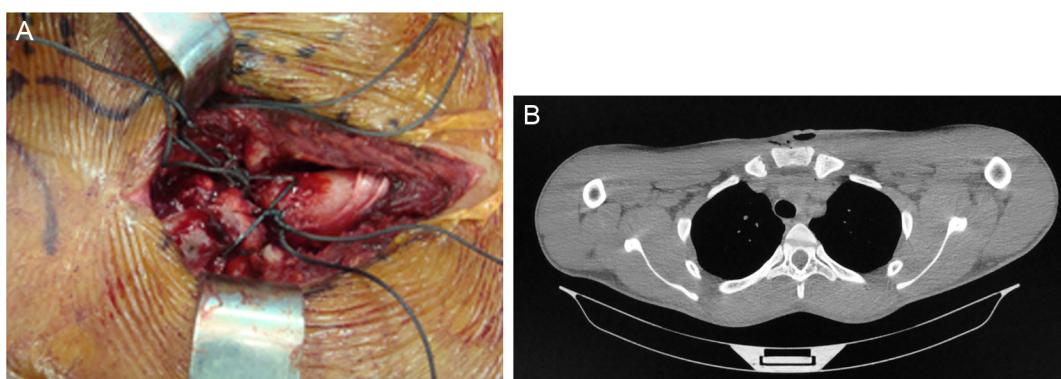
(A) Image of the sternoclavicular joint after open reduction with cerclage; (B) computed tomography showing the left sternoclavicular joint reduced.
